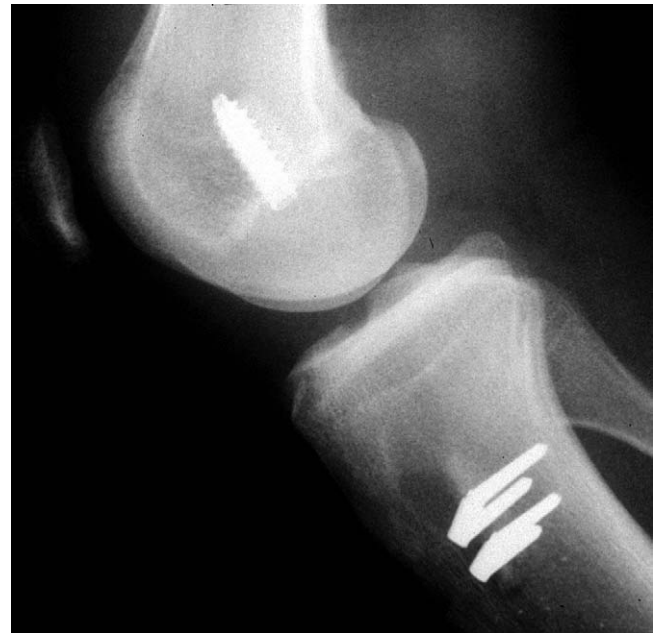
Lateral radiograph depicting anteriorly malpositioned femoral tunnel.
